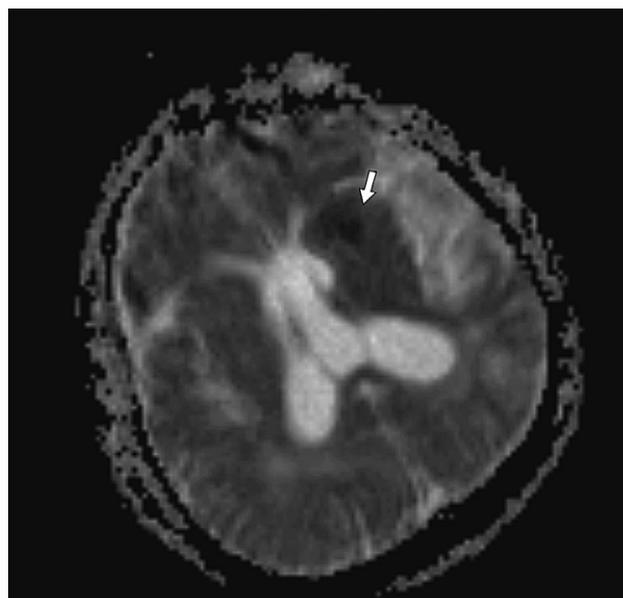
MRI of the patient's brain revealed low apparent diffusion coefficient values involving the left basal ganglion and thalamus.
